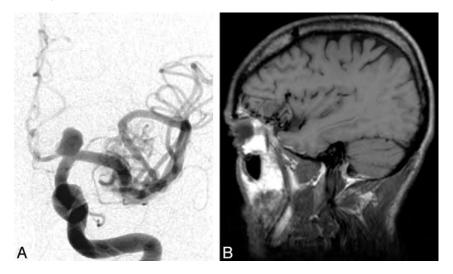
Angiography of the left carotid artery with sagittal TI MR imaging scan of a 54-year-old man with left fronto-insular epilepsy (probable). Angiography shows an arteriovenous malformation fed by the left middle cerebral artery and a left supraclinoid internal carotid artery aneurysm. MR imaging scan reveals the arteriovenous malformation centered on the left frontal operculum with mass effect on the anterior short gyrus of the insula.
